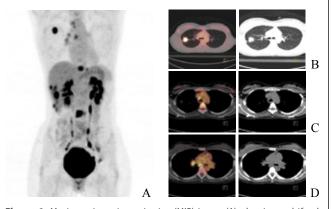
Maximum intensity projection (MIP) image (A), showing multifocal abnormal ¹⁸F-FDG accumulation, indicating severe metastatic disease. Transverse images of the thorax (B) show increased uptake at the upper right lung lobe, corresponding to the primary lesion (SUVmax of 9.4). Hypermetabolic lymph nodes are observed in the mediastinum (paratracheally on the right and subcarinally) as well as in the right pulmonary hilum, with a SUVmax of 4.2 (C, D).
